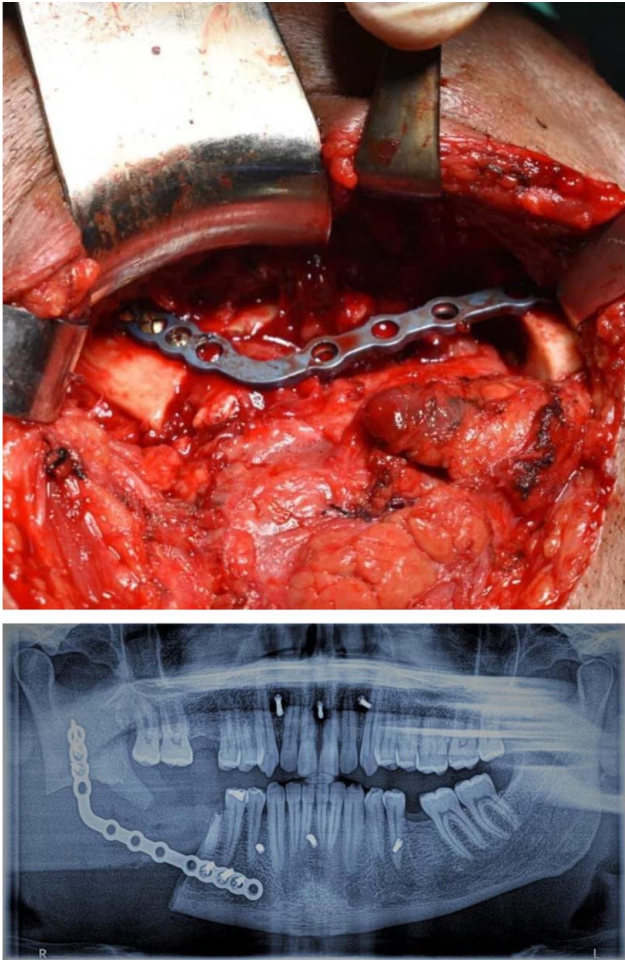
Radiographic and intraoral operative features after applying reconstruction plate.
